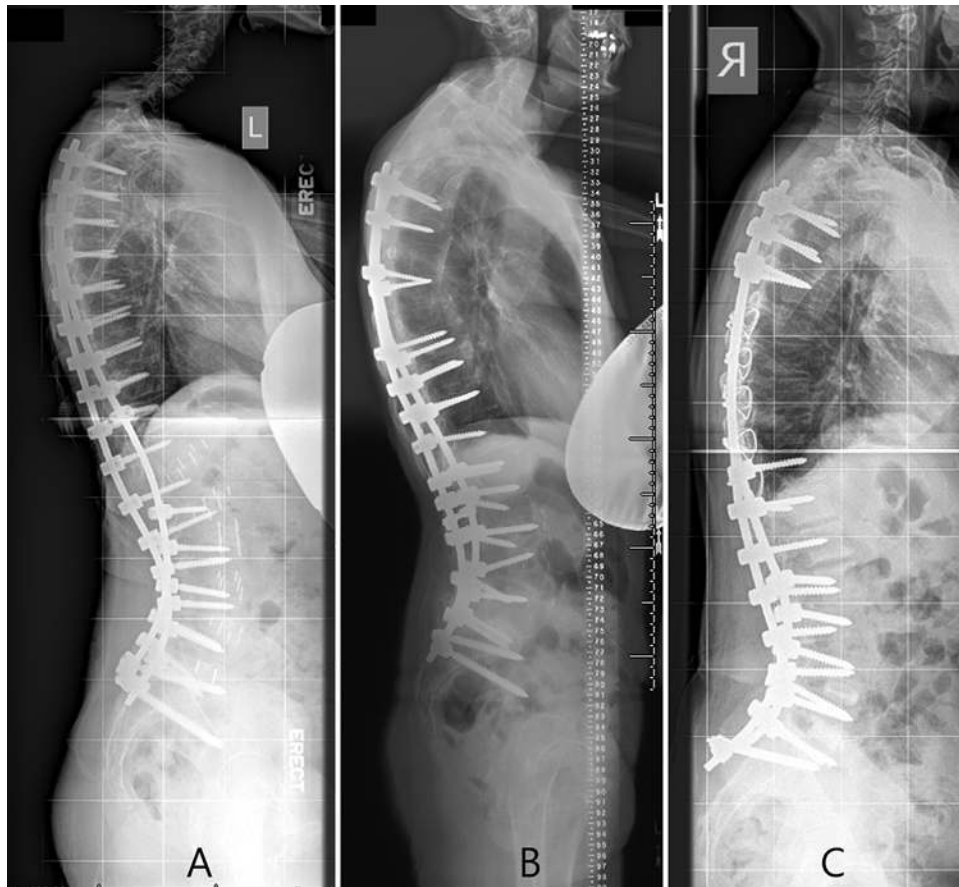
Lateral standing radiographs of patients after surgery. A: LLIF+PSF. B: ALIF+PSF. C: PSF only.
